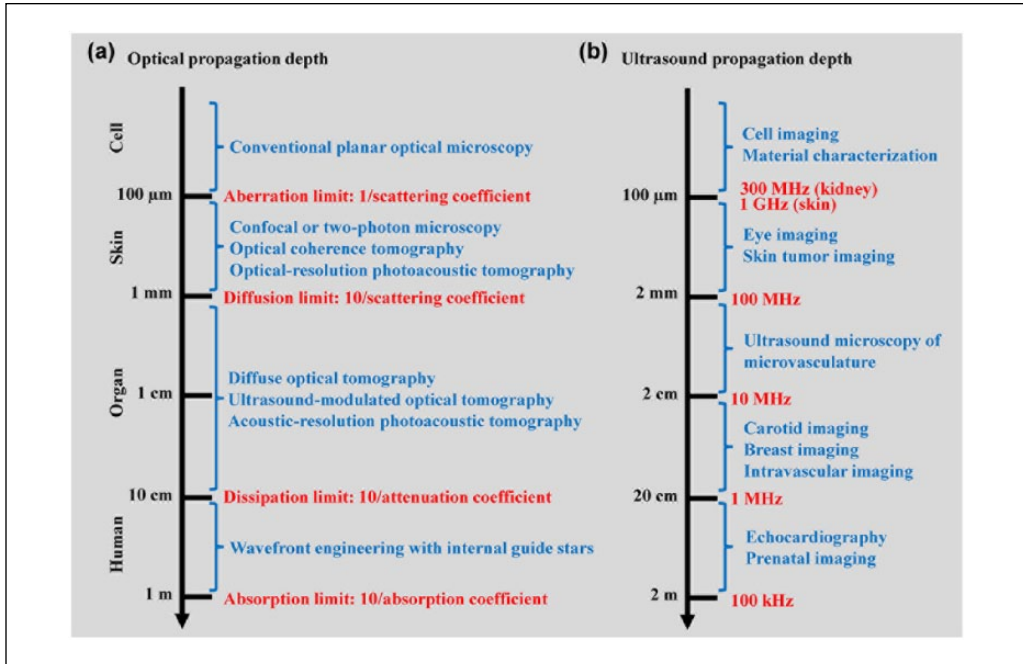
Photon and ultrasound propagation regimes in soft tissue. (a) Photon propagation regimes in soft tissue, which are approximately related to the penetration depths of representative optical imaging modalities.^{5,28} The four regimes are divided at photon propagation depths of 0.1 mm, 1 mm, 10 cm and 1 m, with typical optical absorption coefficient of 0.1 cm^{-1} , optical scattering coefficient of 100 cm^{-1} , and anisotropy of 0.9. The classification holds in optical scattering dominant media. (b) Ultrasound propagation regimes at typical ultrasound frequencies in soft tissue, with corresponding biomedical applications.²⁹ The ultrasound attenuation coefficient is approximately proportional to the ultrasound frequency up to at least 300 MHz for skin³⁰ and 100 MHz for kidney.³¹ Here, the -10 dB propagation depth at the frequency up to 100 MHz is estimated with an ultrasound attenuation coefficient of 0.5 dB/cm/MHz . The propagation depths at 300 MHz for kidney and 1 GHz for skin are extrapolated based on the literature data,^{30,31} taking into account the ultrasound attenuation by water.
